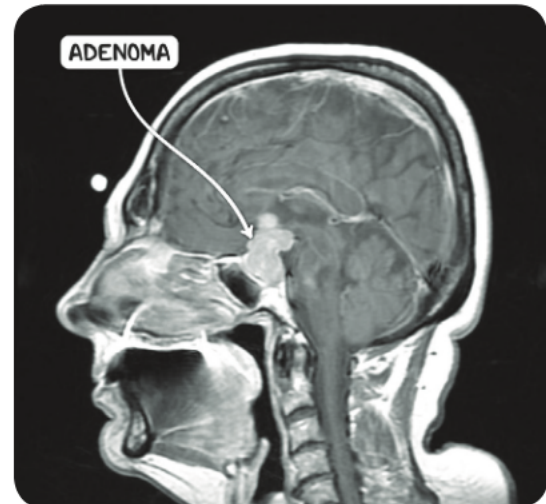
An MRI scan of the head in the sagittal plane demonstrating a large pituitary adenoma.
